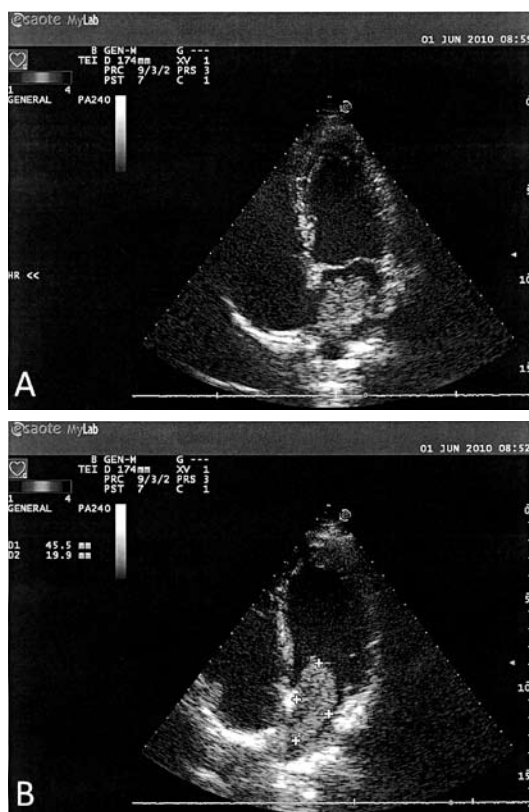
Preoperative transesophageal echocardiography. A) Myxoma of the left atrium, B) the myxoma protruding through the mitral opening in the left ventricle during diastole (Ružička-Kaloci S., 2011)
